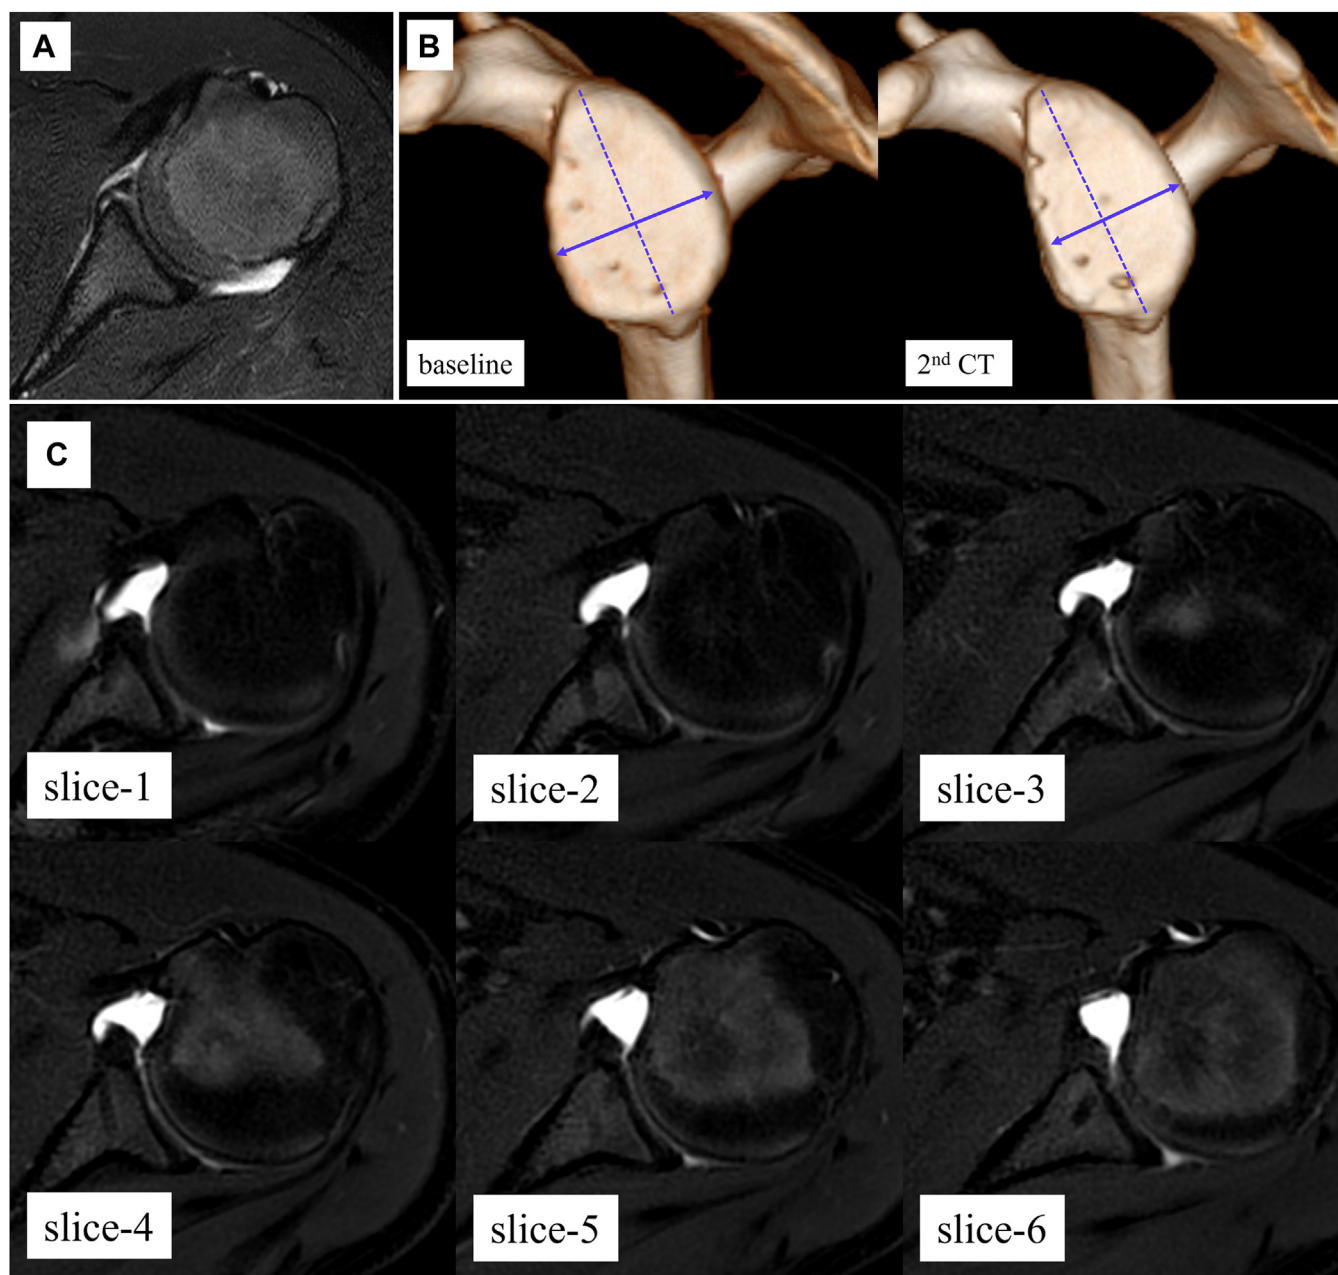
Findings in a 14-year-old boy as a representative case. The image shows marked anterior glenoid rim resorption but complete healing of the capsulolabral complex. (A). Preoperative magnetic resonance image revealed an anterior labrum tear (Bankart lesion). (B). Compared with baseline, the second computed tomography scan at 3 months postoperatively showed marked anterior rim resorption, which corresponded to a reduction in glenoid width of more than 12%. (C). At 5 months postoperatively, magnetic resonance arthrography showed complete healing of the repaired capsulolabral complex in all 6 slices.
